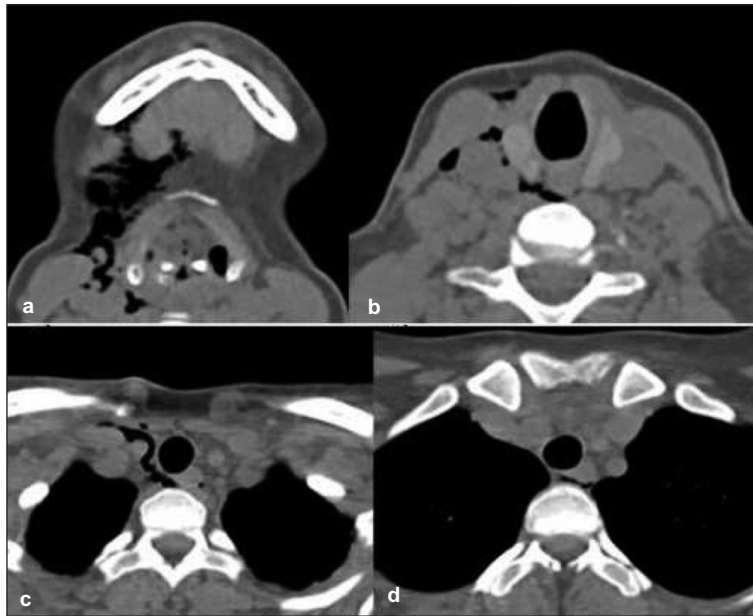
Axial Computed Tomography (CT) scans of neck and chest revealing air densities in the soft tissues extending to mediastinum (Soft tissue window set) on the right side.
